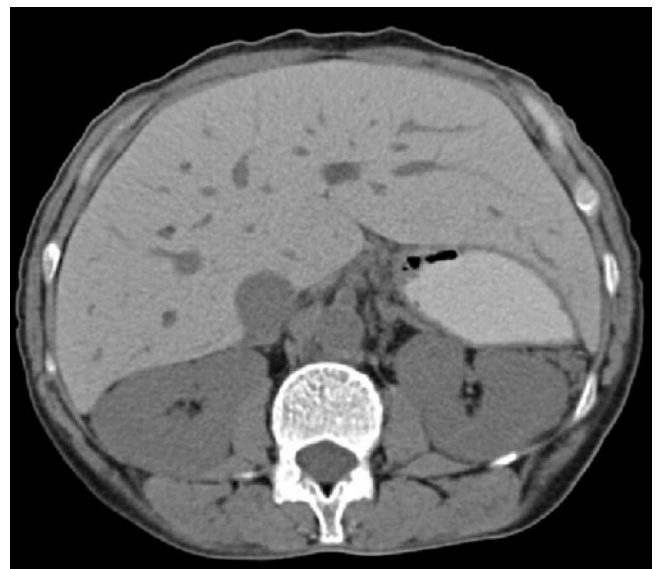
Hemosiderosis. A 45-year-old woman with long history of sickle cell anemia requiring multiple transfusions. Axial non-enhanced computed tomography image demonstrates increased attenuation of the liver. Reproduced from Hodler J, von Schulthess GK, Zollikofer ChL (Eds) (2010) *Diseases of the Abdomen and Pelvis 2010-2013*. Springer-Verlag Italia, Milan, pp. 56-60
